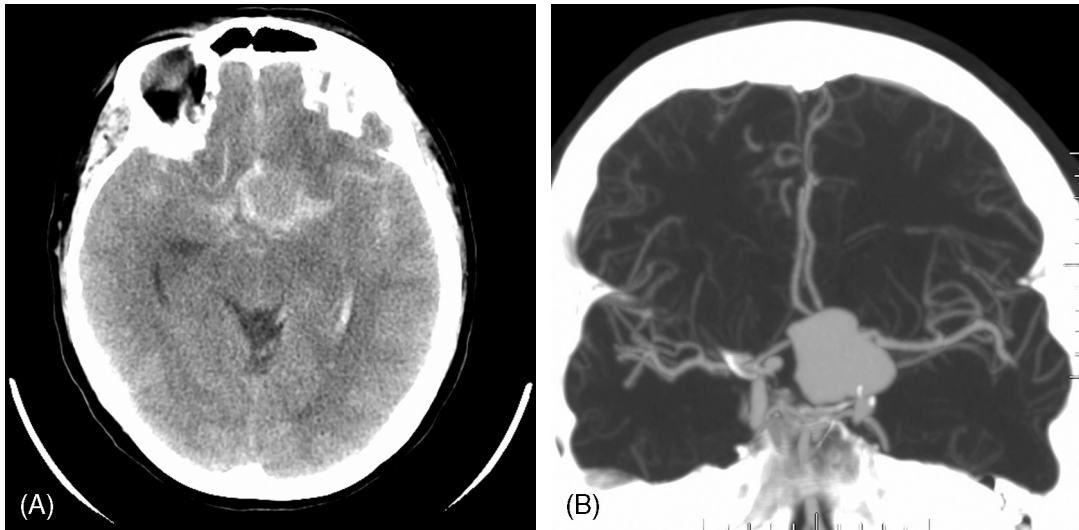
Subarachnoid hemorrhage. (A) Non-contrast head CT shows blood in the interhemispheric fissure and sylvian fissures, as well as a large aneurysm originating in the anterior cerebral artery. (B) CT angiogram reconstruction shows the aneurysm in more detail. The size of this aneurysm would classify it as a “giant” aneurysm.
